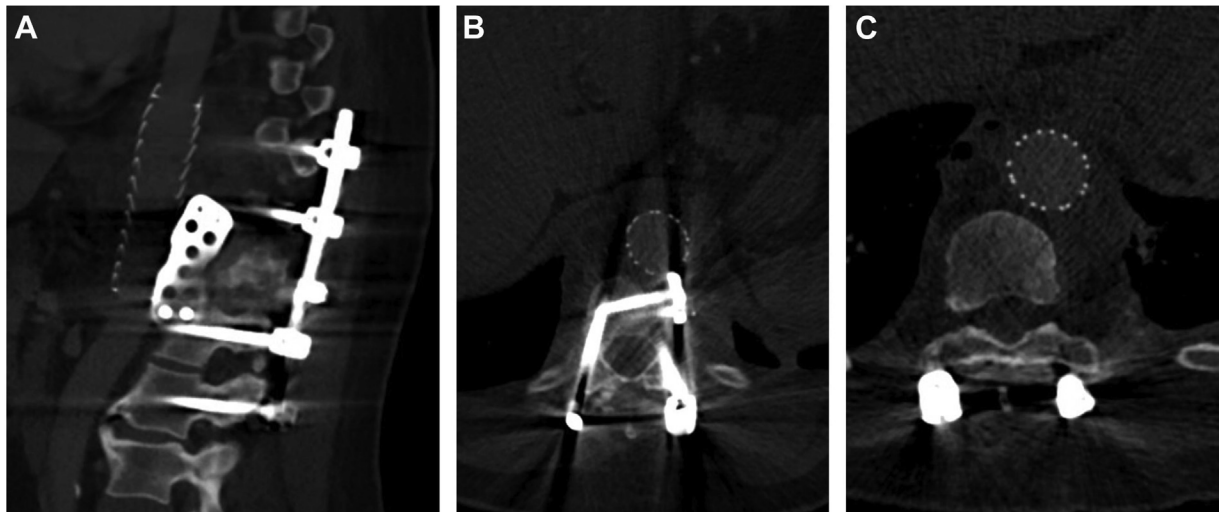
(A) Computed tomography (CT) sagittal view showing impingement of spinal plate into the thoracic endograft (thoracic endovascular aortic repair [TEVAR])/aorta. (B) CT axial view showing impingement of spinal plate into TEVAR/aorta. (C) CT axial view showing thickened pulmonary parenchyma adherent to the TEVAR/aorta.
